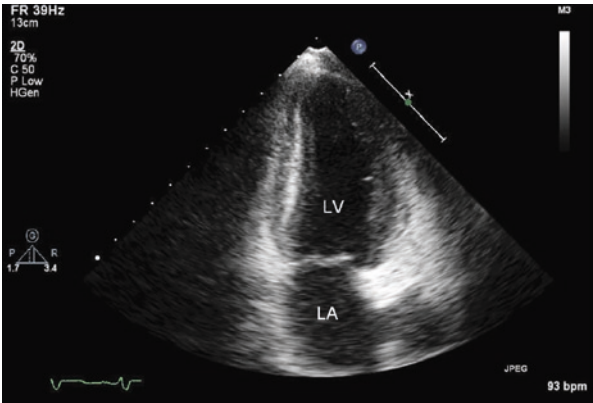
Apical 2 Chamber (2C) view. The 2C view is obtained by starting at the 4C view and rotating the transducer clockwise approximately 90°. In the 2C view, the left ventricle, mitral valve, and left atrium can be seen. The inferior and anterior walls of the left ventricle can be assessed for systolic function. Using color flow and spectral Doppler, the mitral valve can be assessed for regurgitation and stenosis
